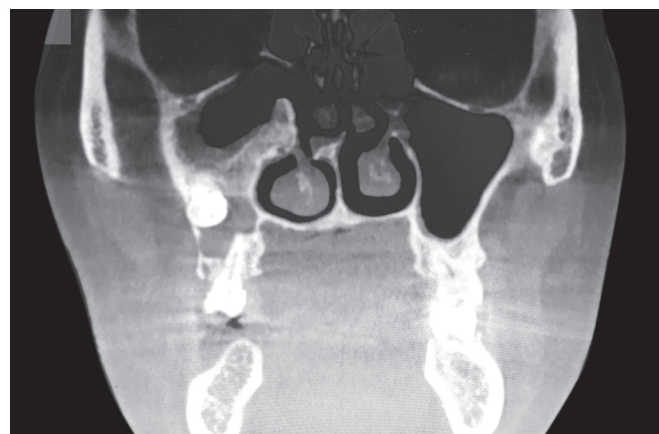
Coronal view of the CBCT showing a hypodense lesion associated with the right maxillary third molar which is partially in the maxillary sinus. The latter also shows a mucosal thickening
